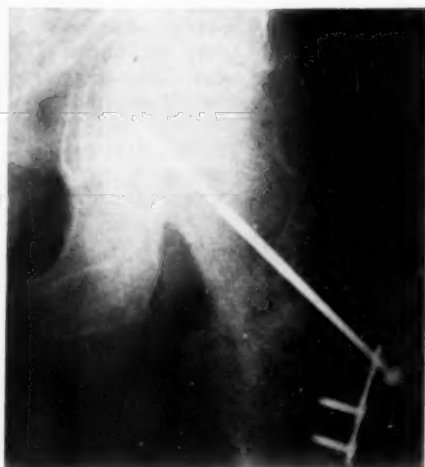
Case No. 679. Roentgenogram of the left femur in the anterior-posterior projection six weeks after surgery.
